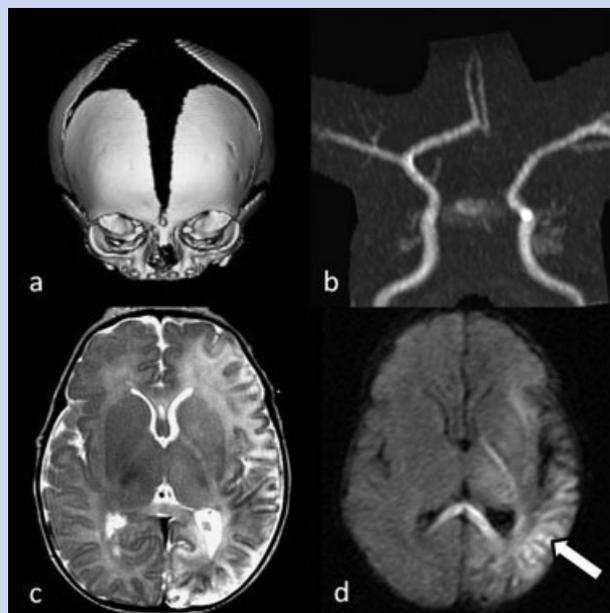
Patient's CT scan and MRA: (a) CNS and craniofacial montage: CT 3D reconstruction at 4 days of age reveals markedly enlarged sutures and anterior fontanel for gestational age. (b) MRA at 9 days of age demonstrates incidental dominant right anterior cerebral artery and bilaterally patent middle cerebral arteries. (c) Axial T2W image and (d) DWI at 9 days of age reveal subacute left hemispheric stroke with persistence of diffusion restriction (arrow).
